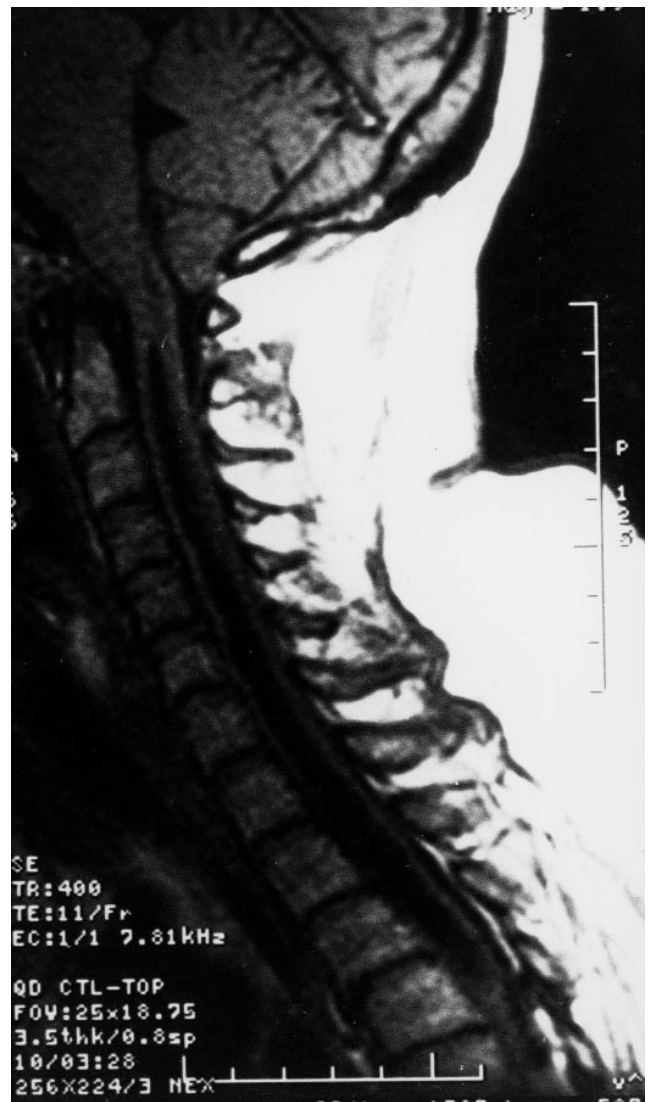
MRI of the cervicothoracic spine showed syrinx spreading from C2 to T7, with cerebellar tonsillar herniation into the foramen magnum.
